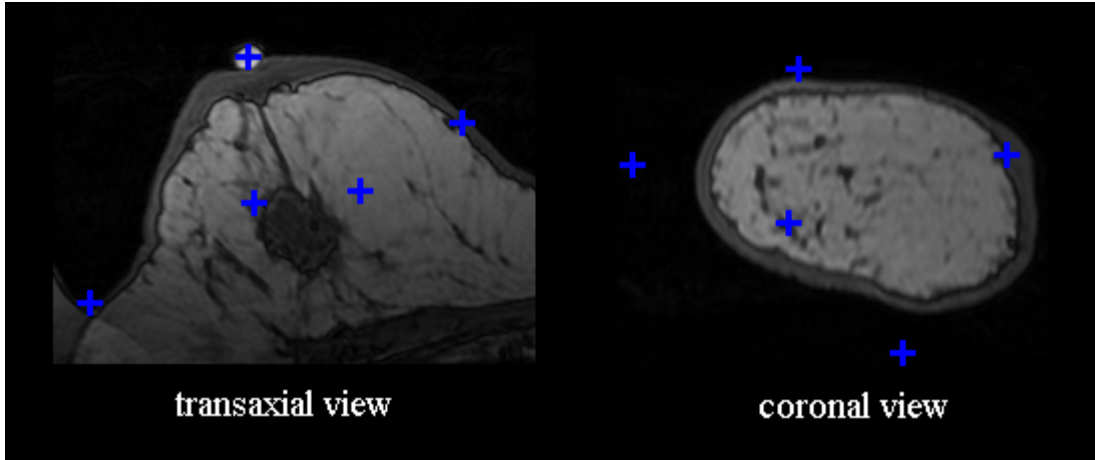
Transaxial and coronal MRI views through middle of breast. Blue marks indicate fiducial marker locations projected onto the slices.
